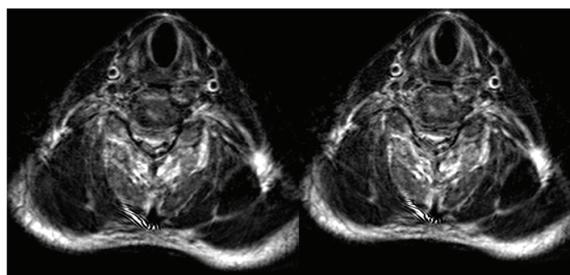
Axial T2-weighted MRI demonstrates markedly compression of C5-6 level
